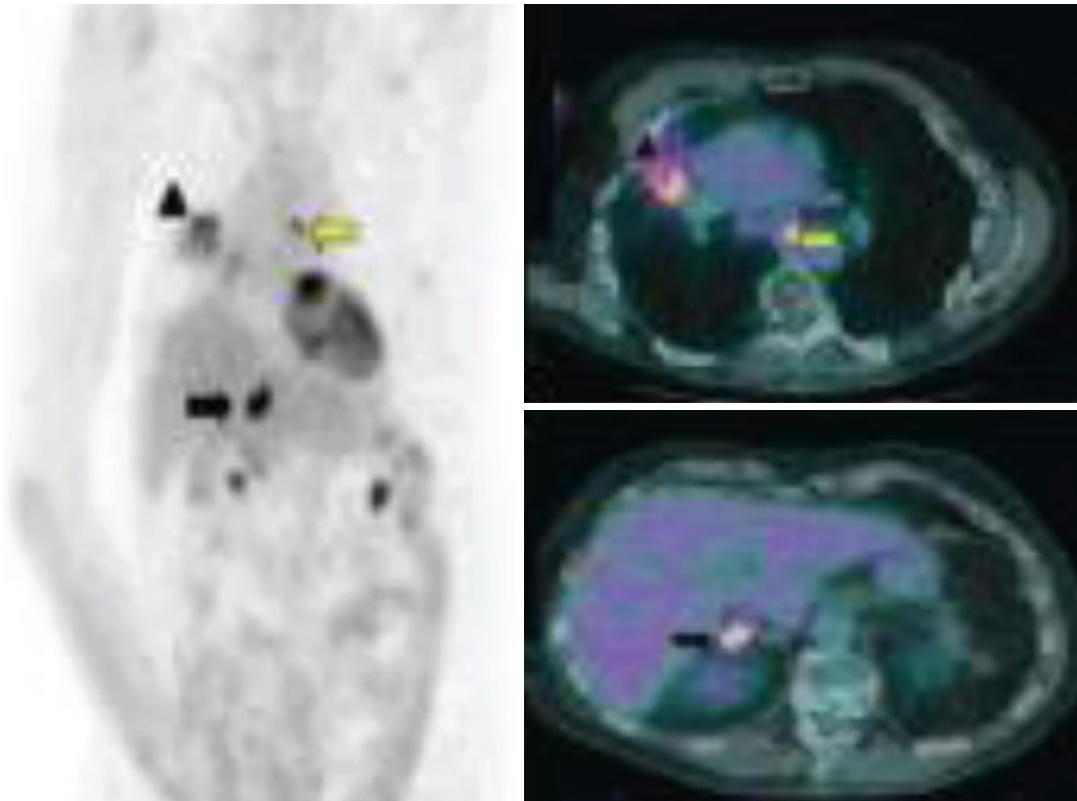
Initial staging of non-small cell lung cancer. MIP image (*left panel*) and fused images (*right panel*) of 18 F-FDG PET-CT showed the primary tumor
